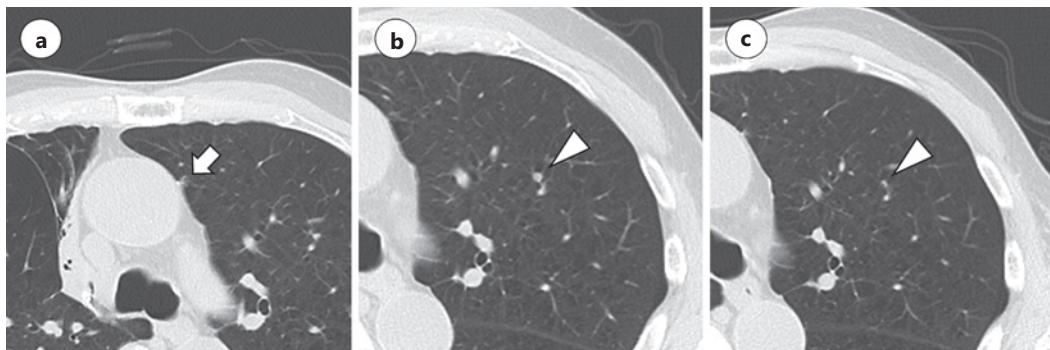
CT findings at 2 and 7 months after SBRT. a, b At 2 months after SBRT, the irradiated lesion regressed (arrow), and the nonirradiated lesion shrunk (arrowhead). c At 7 months after SBRT, the nonirradiated lesion regressed (arrowhead).
